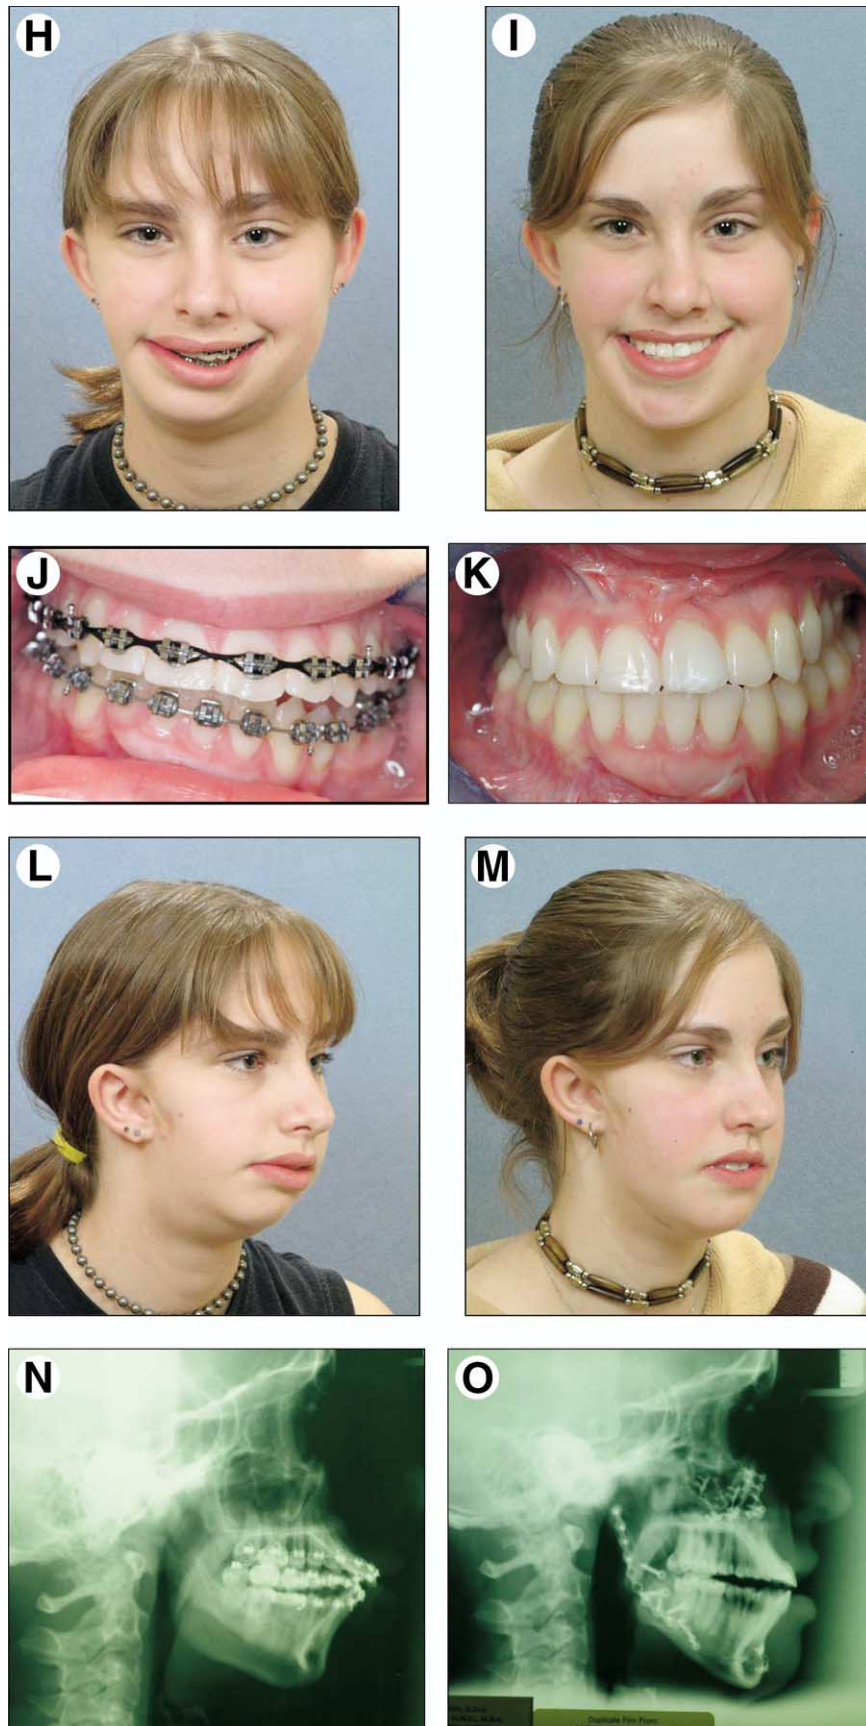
(cont'd). H, I, Frontal smile views before and after reconstruction. J, K, Occlusal views before and after reconstruction. L, M, Oblique facial views before and after reconstruction. N, O, Lateral cephalometric radiographs before and after reconstruction.
